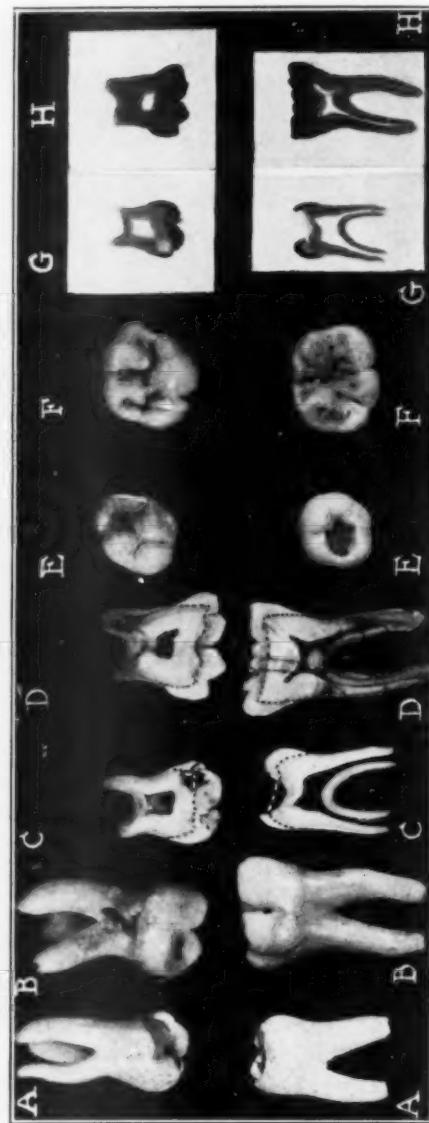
Extracted bud type and normal upper and lower first molars of second dentition. A and B, note difference in size and form of bud molars (A) and normal molars (B). C and D, mesiodistal ground sections of bud molars (C) and normal molars (D). The significant difference is in the outline of the dentinoenamel junction. E and F, note difference in size and form in the occlusal view of bud molars (E) and normal molars (F). G and H, roentgenograms of ground sections of bud molars (G) and normal molars (H).
